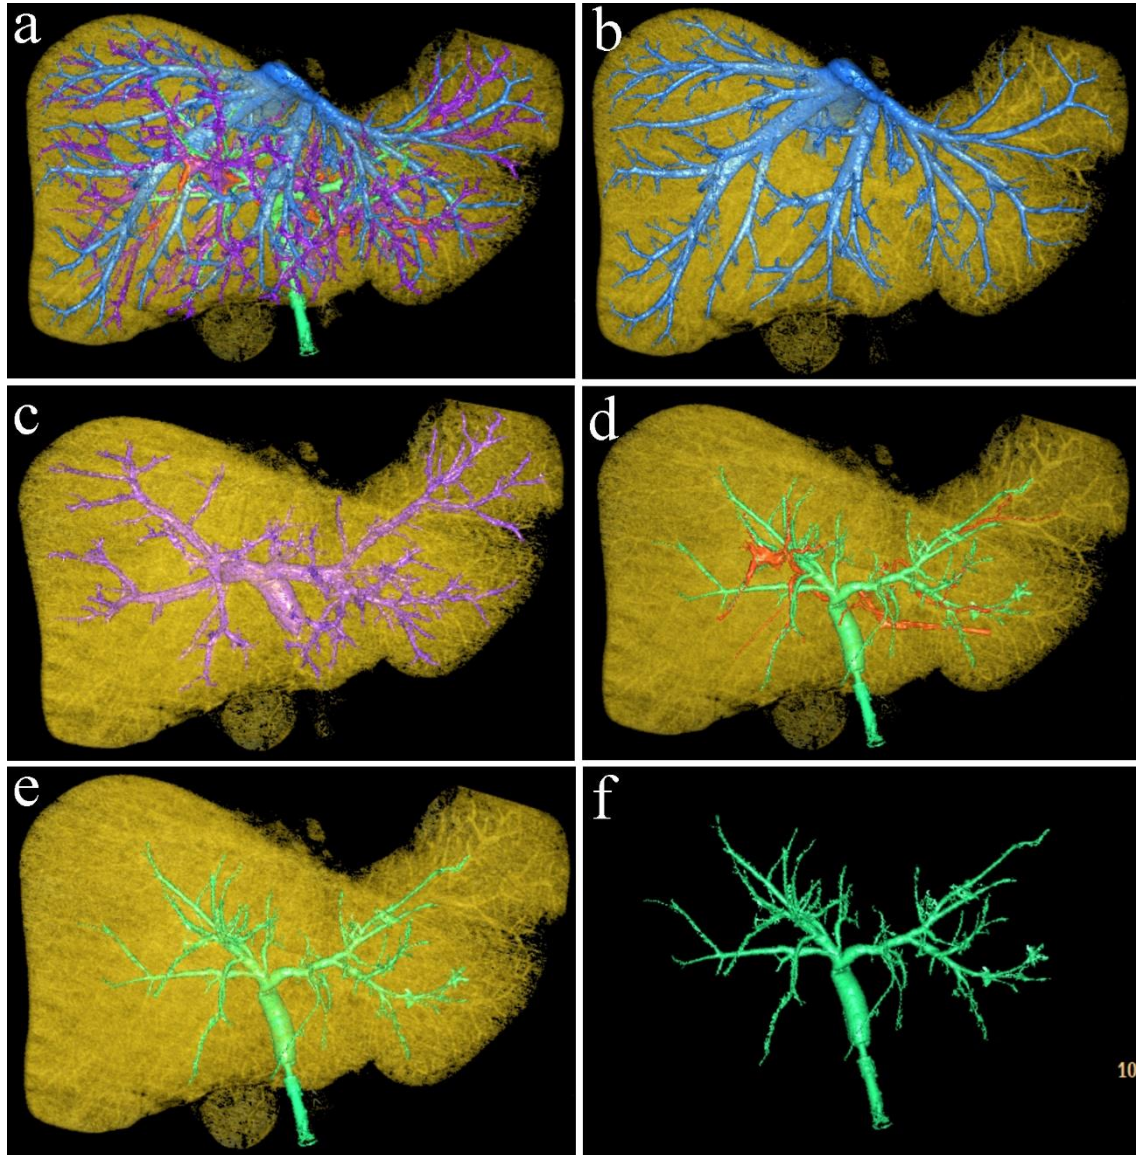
CT scans of a human liver preparation with specially adjusted CT density for the different vessels and bile ducts. The different structures can be visualised (and colour coded) separately or all together (with or without the parenchyma) because of the appropriately different CT density. IVC and hepatic veins - blue, portal vein - purple, hepatic duct - green, hepatic artery - red (Source: author's own work. Co-workers: Zsuzsanna Kürti, Ibolyka Dudás, Zsolt Pápai, András Szuák).
